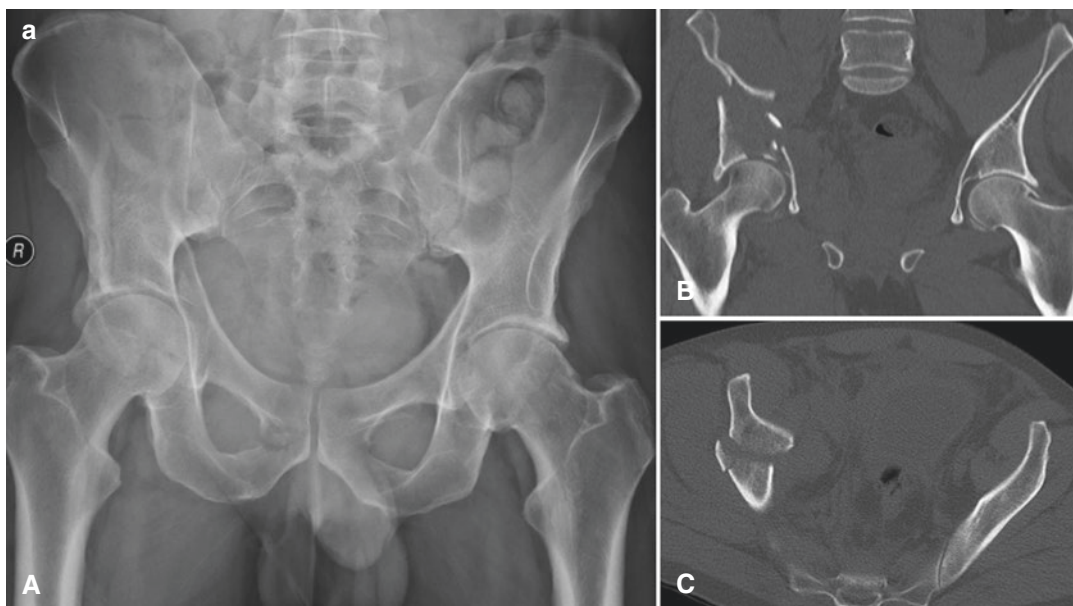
(a) Pre-operative radiographs (A: AP pelvis; B: CT coronal, C: CT axial cuts) of a two-column right acetabulum fracture. (b) Postoperative radiographs following reconstruction (A: Pelvic inlet view, B: Obturator oblique, C: Iliac oblique)
